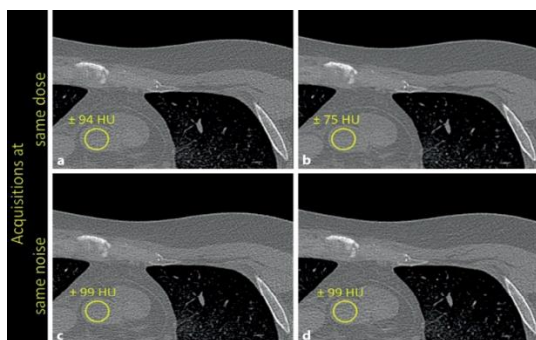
CT Image in Effected Noise
